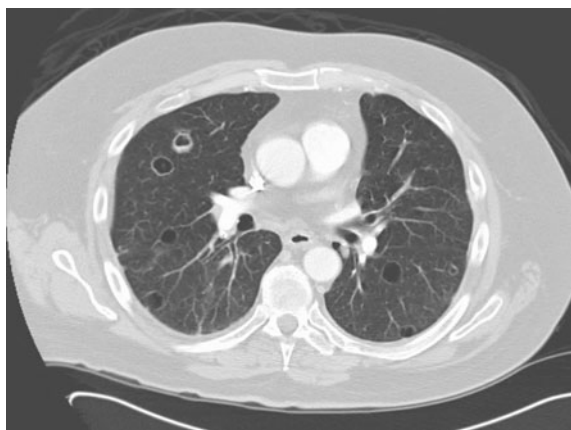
Chest computed tomogram performed after lung re-expansion and six total weeks of sunitinib therapy demonstrating multiple cavernized lung nodules
